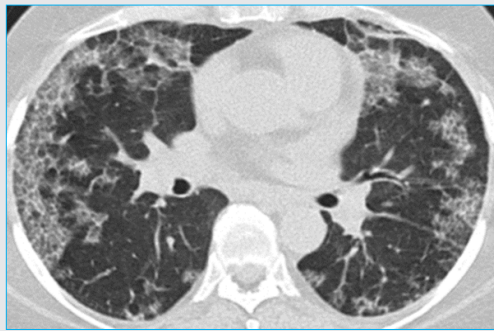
Axial section of a CT scan of a patient with COVID-19 showing prominent interlobular and intralobular septal thickening on a background of bilateral, multifocal and peripheral GGO; features of crazy paving.
